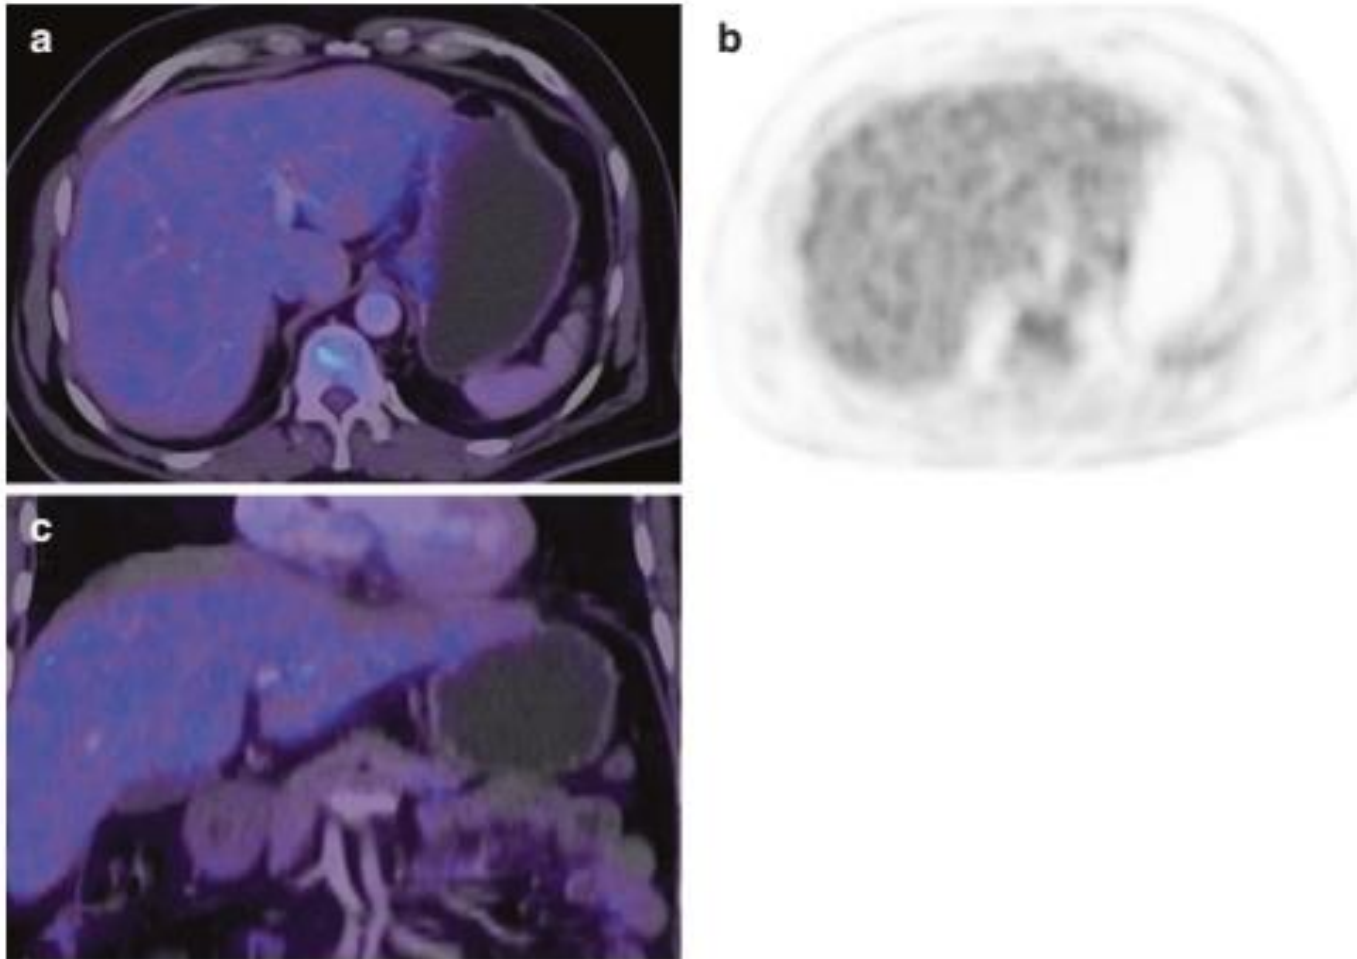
Physiological FDG uptake in the liver (a, c). Fine mottled appearance of physiological FDG uptake in the liver made out in PET image.
